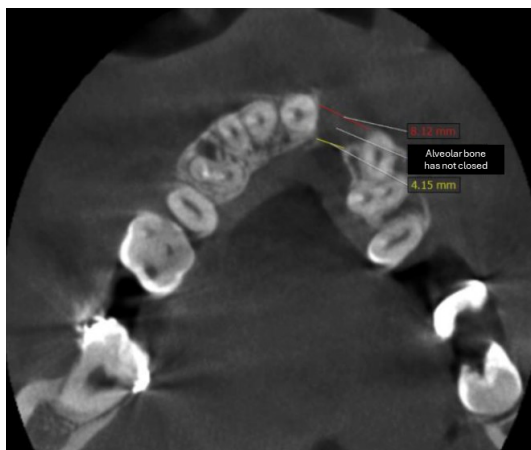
Axial CBCT examination shows the bone defect and an absence of the lateral left incisor
